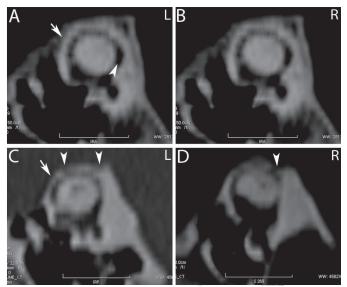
Computed tomography comparison of superior semicircular canals (SSC) between the patient showing superior semicircular canals dehiscence (SSCD) syndrome and a patient without vertigo. Temporal bone volume CT was performed using a Toshiba Aquilion One 640 CT machine. (A, B) Normal SSC of a patient without vertigo exhibited a continuous high intensity signal of the bony wall (arrow) and dark region of the membranous SSC (arrowhead), (C, D) The patient with SSCD syndrome exhibited a thin SSC wall (arrow) and fractures (arrowheads).
